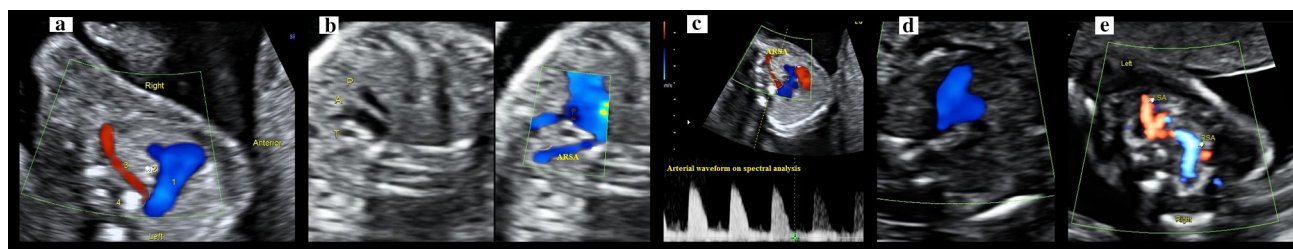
Gray scale, color Doppler, and spectral Doppler images of ARSA and normal subclavian arteries. a Axial three vessel trachea view showing (1) Color confluence of aortic and ductal arches, (2) Trachea, (3) ARSA, and (4) Spine. b Coronal plane, combined gray scale and color Doppler demonstration of ARSA. c Spectral Doppler confirmation of the ARSA with the arterial waveform. d Normal three
